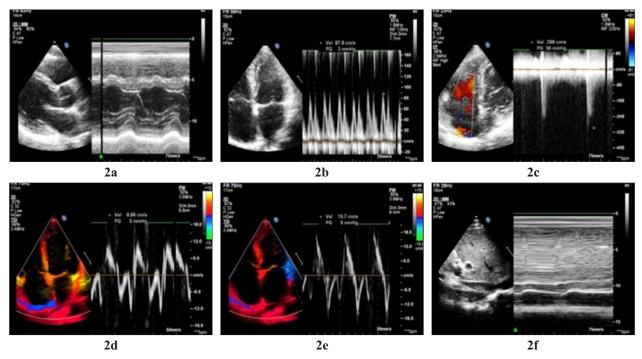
Repeat 2d Echocardiography around 9 months showing normal ventricular septal shift i.e. no septal bounce (2a), normal respiratory variation in ventricular filling i.e< 25% respiratory variations in mitral valve inflow pattern (2b), mild pulmonary hypertension (2c), normal tissue doppler imaging (2d, 2e), normal inferior vena cava (2f).
